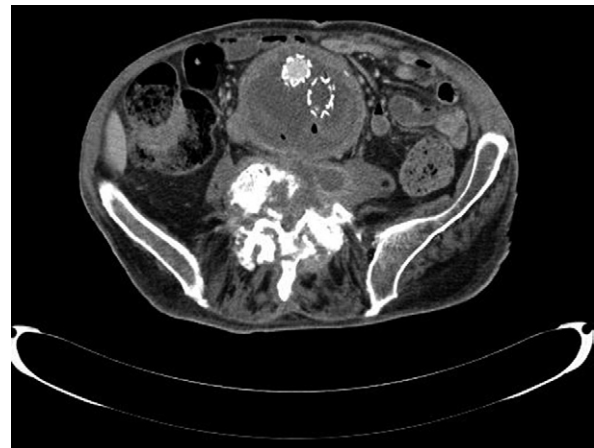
Axial computed tomography (CT) image at 6 months showing essentially static appearances.
